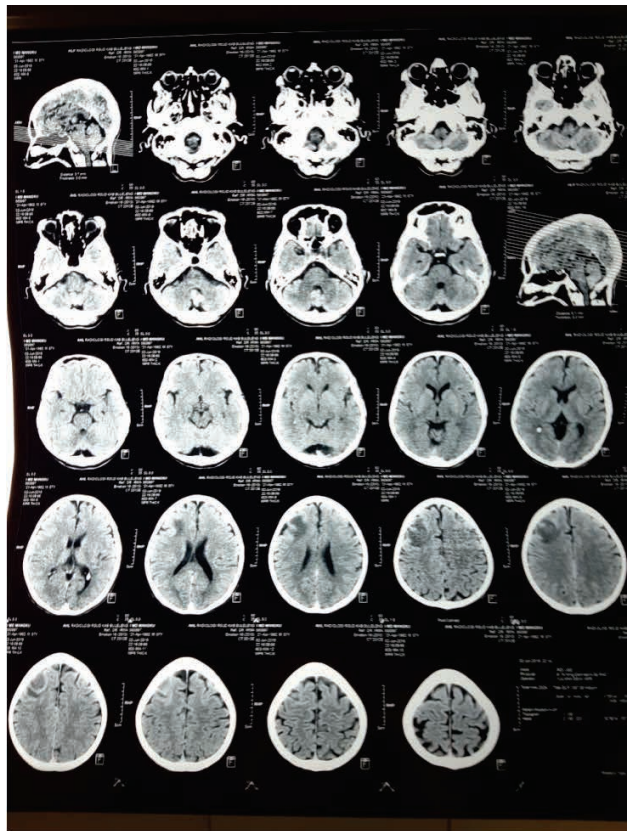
A CT scan of the head shows a solitary lesion with clear boundaries on the right frontal lobe with finger-like edema around it that urges and constricts the right lateral ventricle, supporting the picture of a primary brain tumor with suspicion of intratumoral bleeding, cerebral edema
